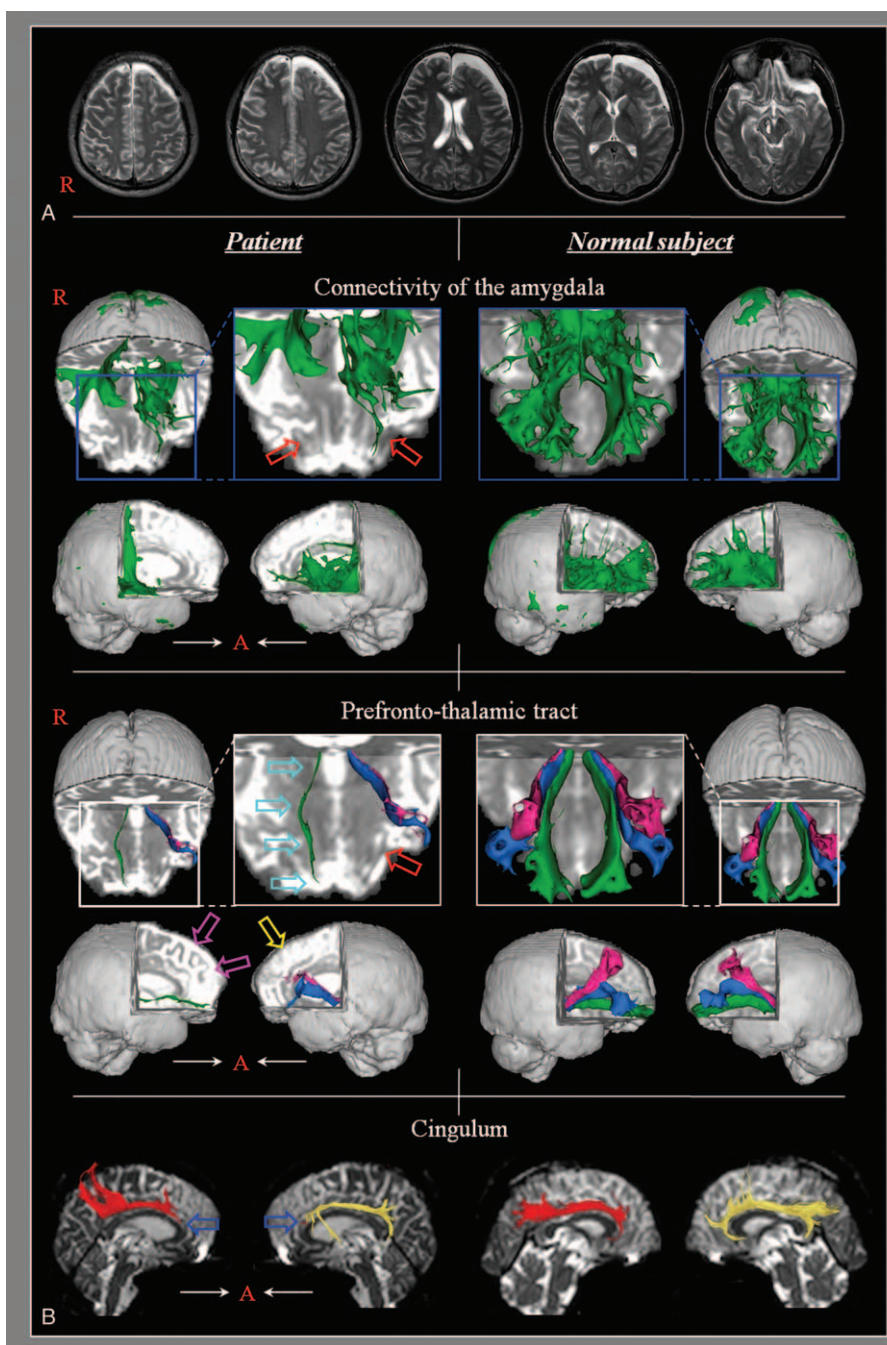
(A) Brain MR images subdural hemorrhage on right temporo-parieto-occipital lobe and multiple hemorrhage in the right midbrain and both frontal and temporal lobes at 10 months after onset are observed. (B) On 10-month diffusion tensor tractography, the neural connectivity of amygdala to the prefrontal cortex including orbitofrontal cortex is decreased in both hemispheres (red arrows). Regarding the prefronto-thalamic tracts, orbitofrontothalamic tracts present narrowing (right side, sky blue arrows) and nonreconstruction (left side, red arrow). In addition, nonreconstruction of the ventrolateral and dorsolateral prefronto-thalamic tracts in the right hemisphere (purple arrows) and narrowing of the dorsolateral prefronto-thalamic tract in the left hemisphere (yellow arrow) are revealed. In the anterior cingulate cortex, discontinuations of both anterior cingulum are observed in both hemispheres (blue arrows).
